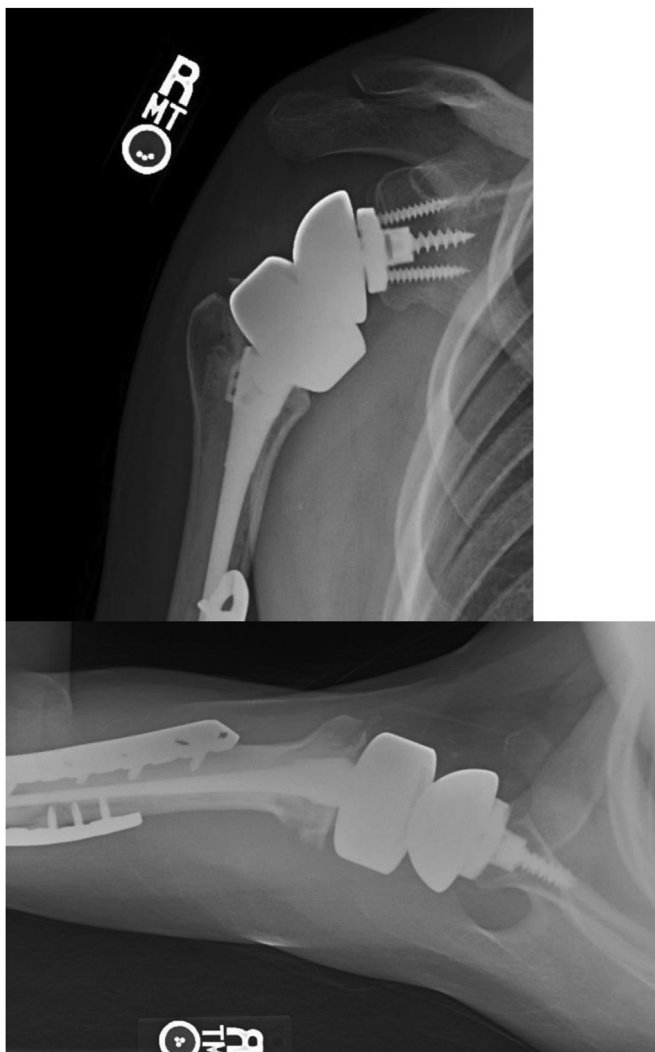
Postoperative radiographs at 28 weeks. There were no issues with hardware seen.
